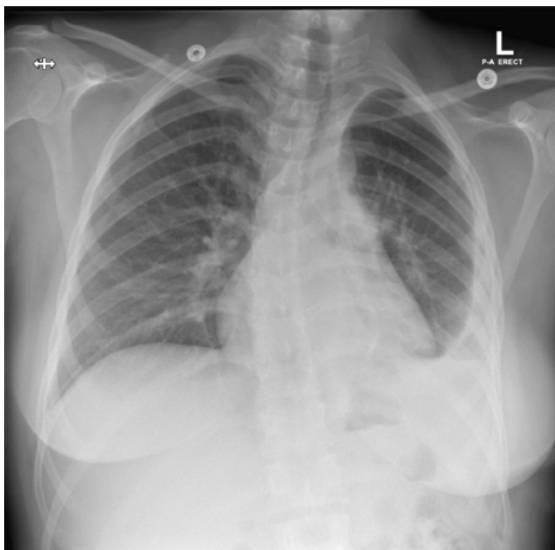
A chest X-ray showed the previously seen left-sided chest tube had been removed. Mild left-sided pleural effusion showing no significant changes since the previous examination. Previously observed subcutaneous emphysema has resolved
